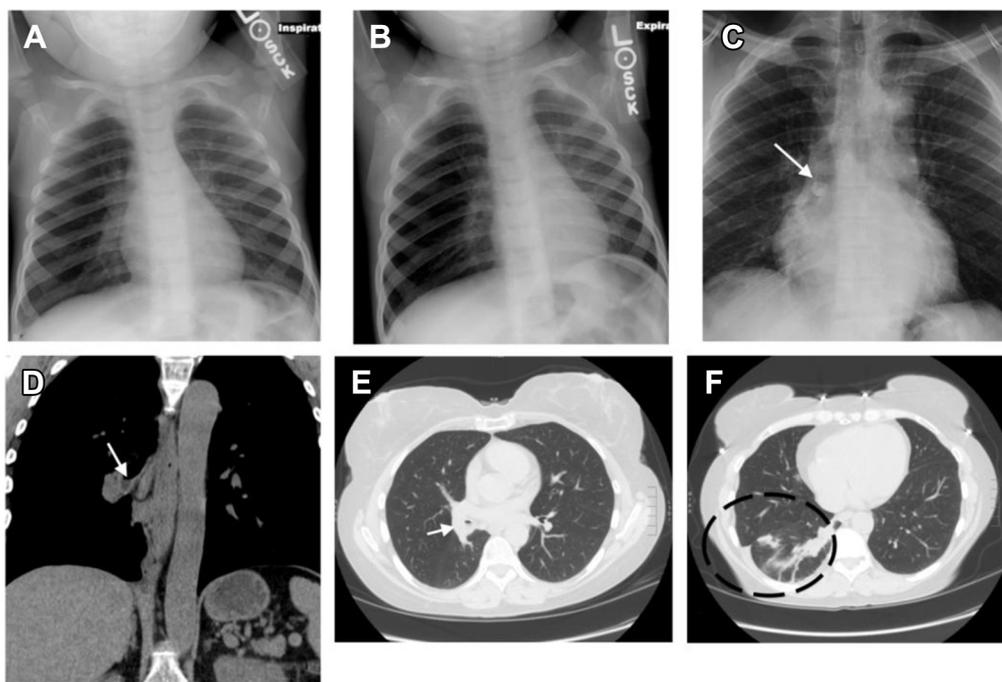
Peanut aspiration in a child. No radiopaque object was identified on frontal radiograph (A). On expiratory view (B), prominent air trapping was observed in the right lung, suggesting obstruction of the right main bronchus. A peanut was subsequently found in the right main bronchus by bronchoscopy. C, A radiopaque tooth in the bronchus intermedius (white solid arrow) on frontal chest radiograph. Coronal (D) and axial (E, F) noncontrast chest CT images of the same patient who aspirated a peanut. White solid arrows in D and E point to a filling defect in the bronchus intermedius (note the narrowed bronchus). Black dashed circle in F demonstrates postobstructive atelectasis. A peanut was subsequently found in the bronchus intermedius by bronchoscopy.
